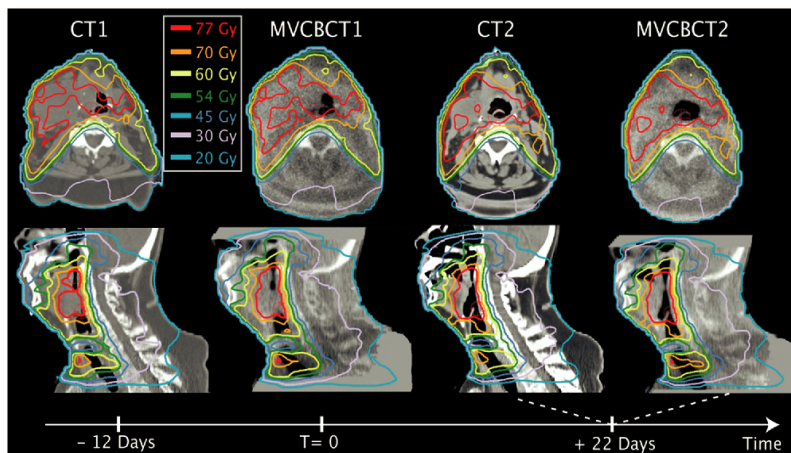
Dose calculation for patient treated for base-of-tongue tumor with intensity-modulated radiotherapy. Initial plan defined on initial CT (CT1) applied on megavoltage cone-beam CT (MVCBCT) acquired in first week of treatment (MVCBCT1) and additional CT (CT2) and MVCBCT (MVCBCT2) acquired 22 days after beginning of therapy. Axial and sagittal images crossing isocenter show good qualitative agreement between isodose lines (CT1 with MVCBCT1 and CT2 with MVCBCT2).
